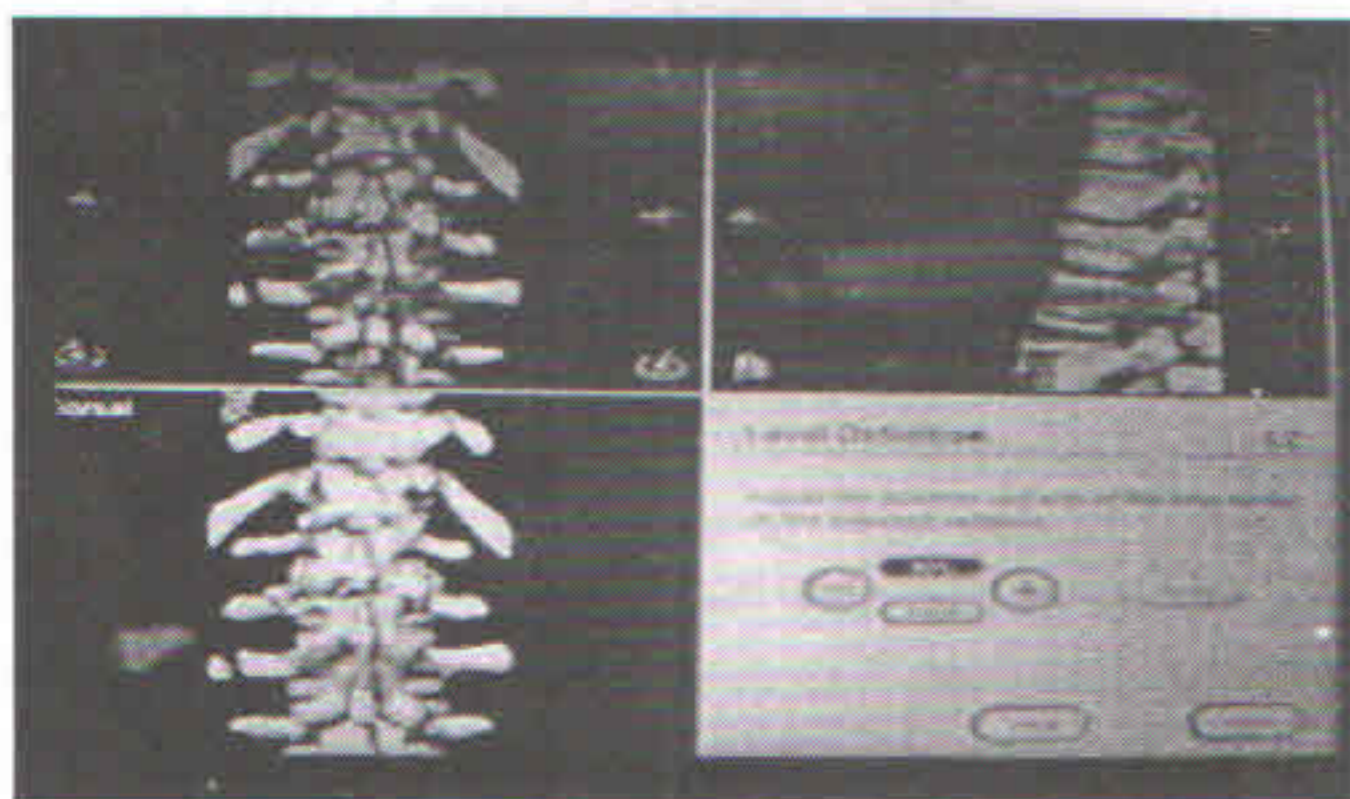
3D CT picture seen in computer navigator
